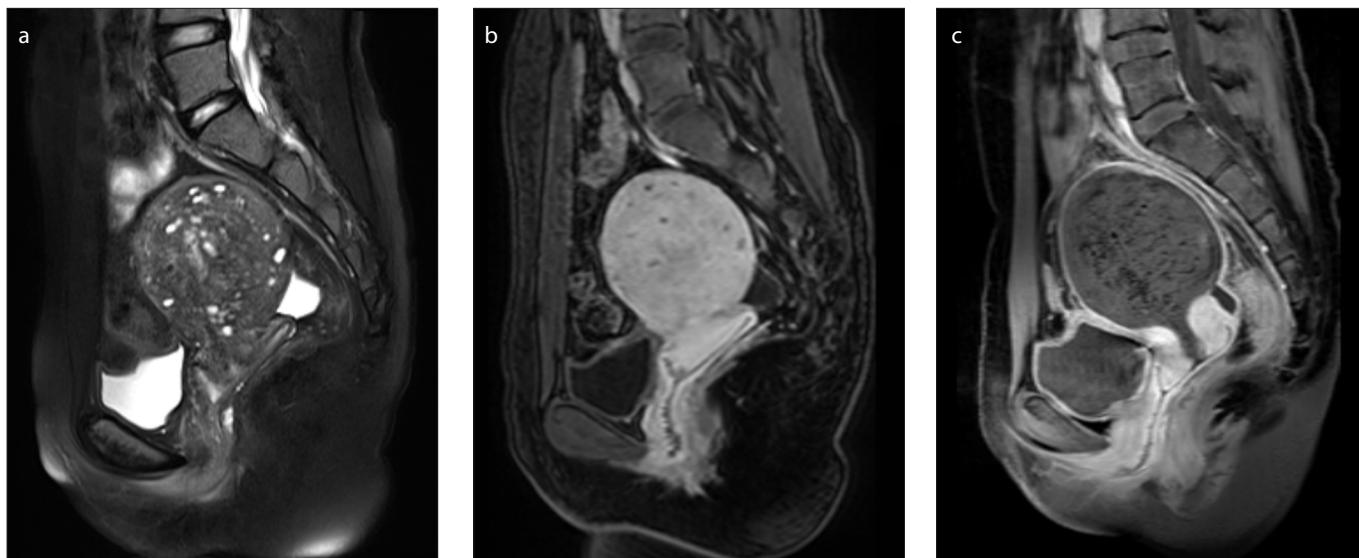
a–c. MRI of a 35-year-old woman with diffuse adenomyosis who did not have endometriosis. Her serum CA125 level was 85.5 U/mL. Preprocedural sagittal T2-weighted image (a) shows a diffuse thickening of the junctional zone accompanying punctate T2 high signal intensity myometrial foci, which almost occupies the whole myometrium. Preprocedural sagittal contrast-enhanced T1-weighted image (b) shows homogeneous enhancement of lesion. Follow-up sagittal contrast-enhanced T1-weighted image (c) 10 days after UAE shows a well-defined necrosis completely replacing the adenomyosis, which represents complete necrosis.
